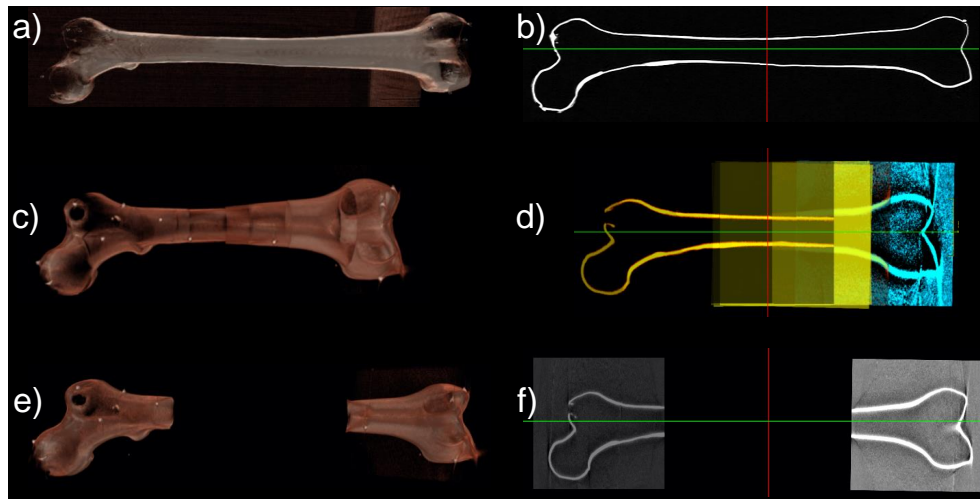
(a-b), (c-d), and (e-f) are volume rendering and single CT slice of the CT, stitched volume using image-based registration, and the non-overlapping stitched volume, respectively. Image-based registration shown in (c-d) uses seven overlapping CBCT volumes and results in significantly shorter total length of the bone (results in Table 5.2). This incorrect alignment is due to insufficient amount of information in the overlapping region, especially for volumes acquired from the shaft of the bone. Shaft of the bone is a homogeneous region where the registration optimizer converges to local optima.
